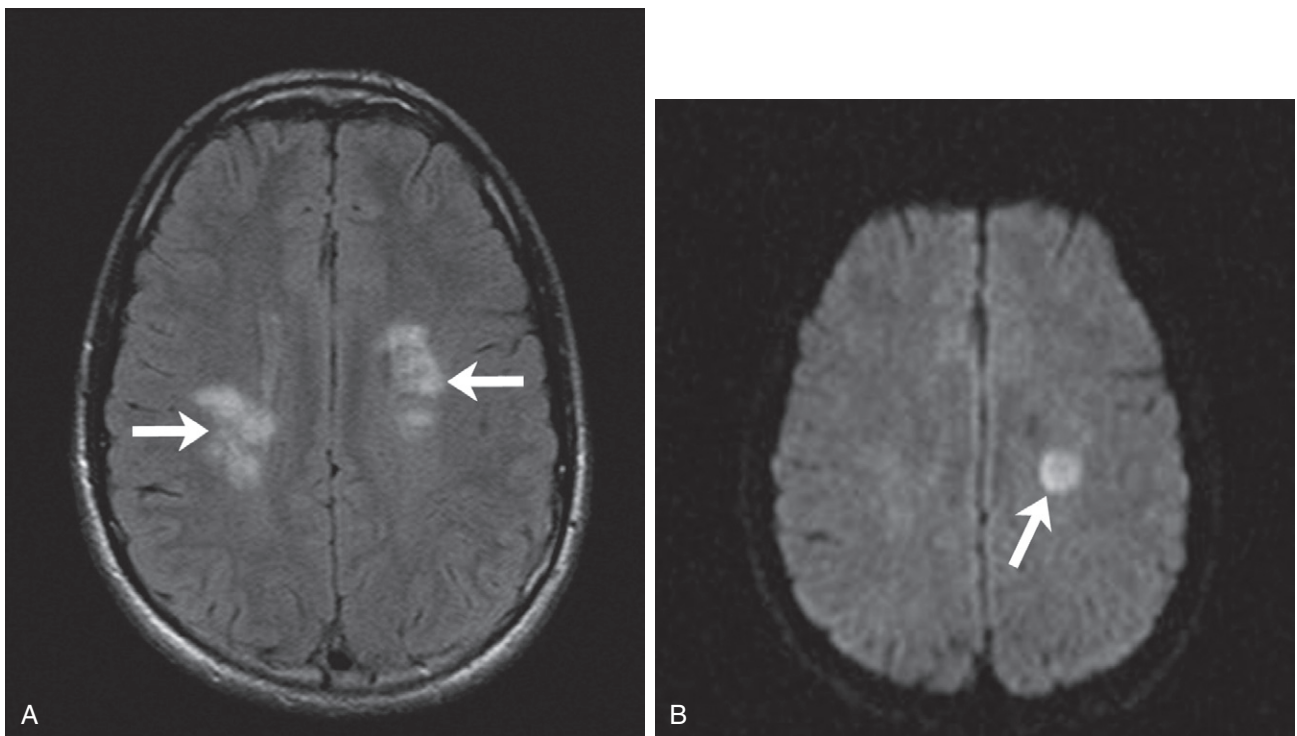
Multiple sclerosis in a 16-year-old child. A, FLAIR MRI shows bilateral white matter lesions. B, DWI demonstrates restriction of the left centrum semiovale lesion that was enhanced on postcontrast T1 MRI (not shown), suggesting an acute or active lesion (*arrow*).
